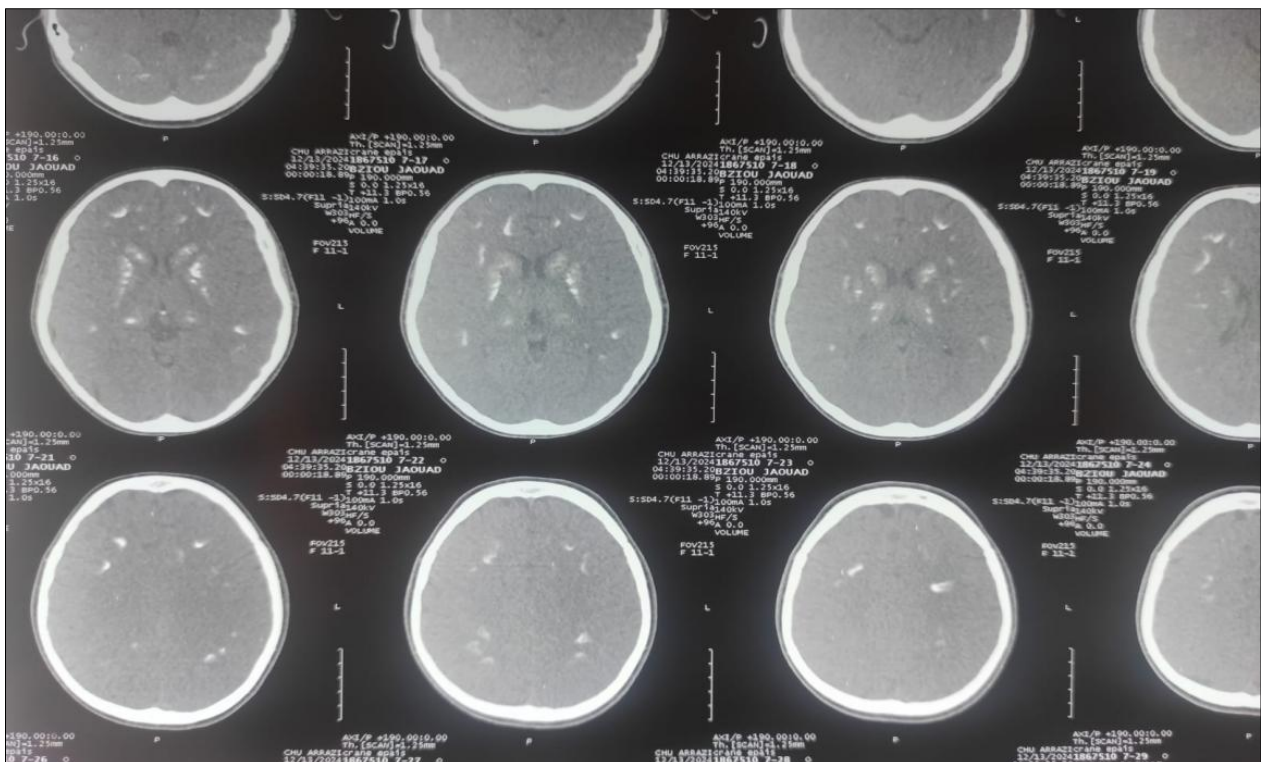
Computed tomography scan of the head showing deep, bilateral, and symmetrical calcifications located in both supra- and infratentorial regions
